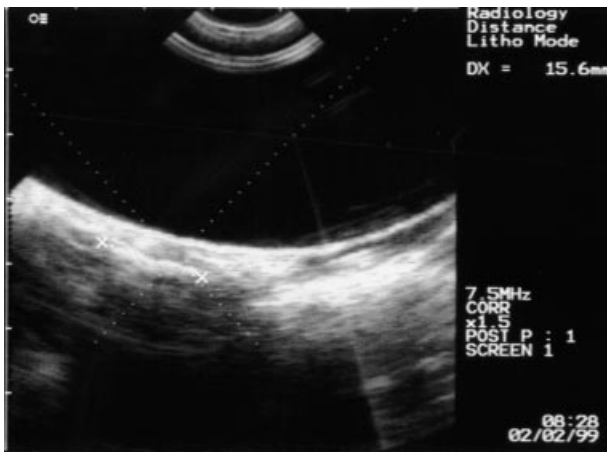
Localizing a Peyronie's plaque using ultrasonography before treatment.
